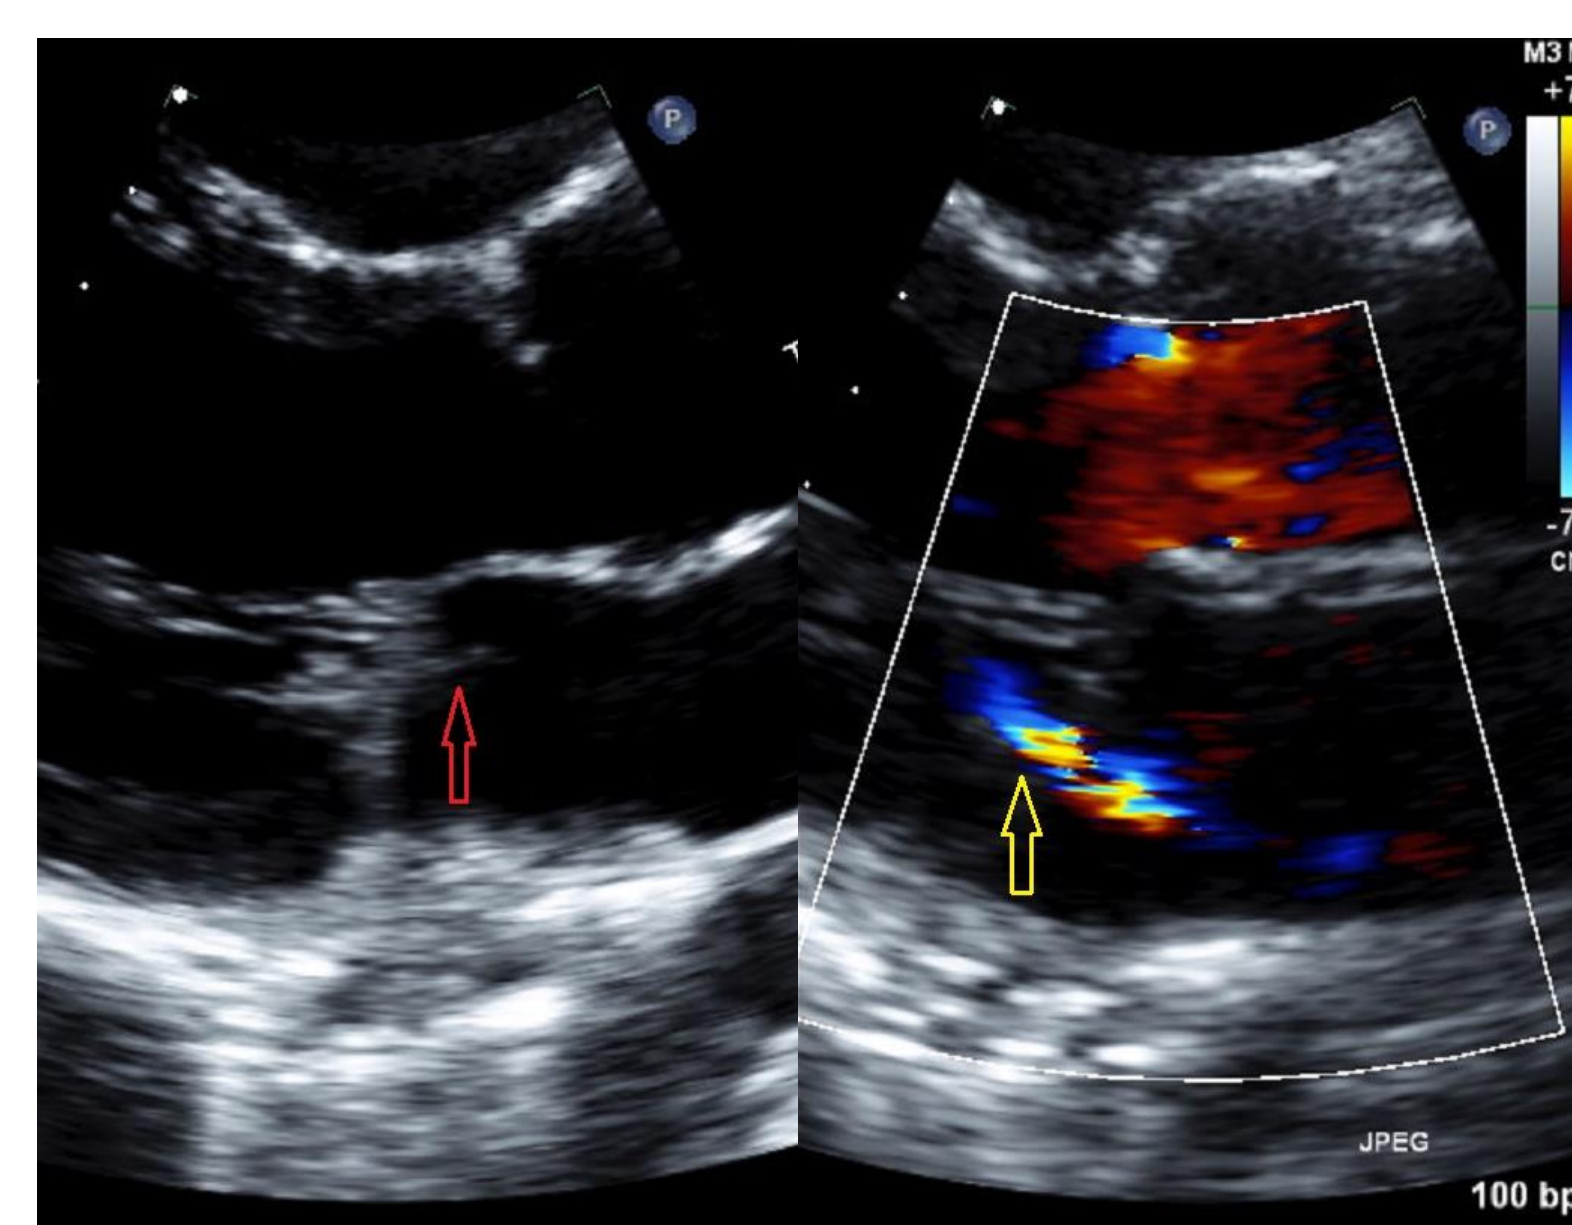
Patient A – Transthoracic echocardiogram demonstrated a myxomatous mitral valve. A mobile echo-density (red arrow) was seen attached to the posterior leaflet suspicious for endocarditis. There is an associated mild grade mitral regurgitation (yellow arrow).
